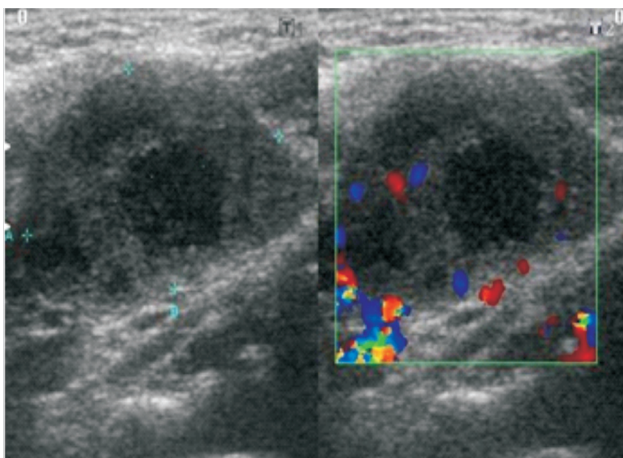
Typical reactive node: Sonographic appearance of lymph nodes the enlarged lymph node is elongated, oval, with center necrotic area and shows the peripheral vascularity
